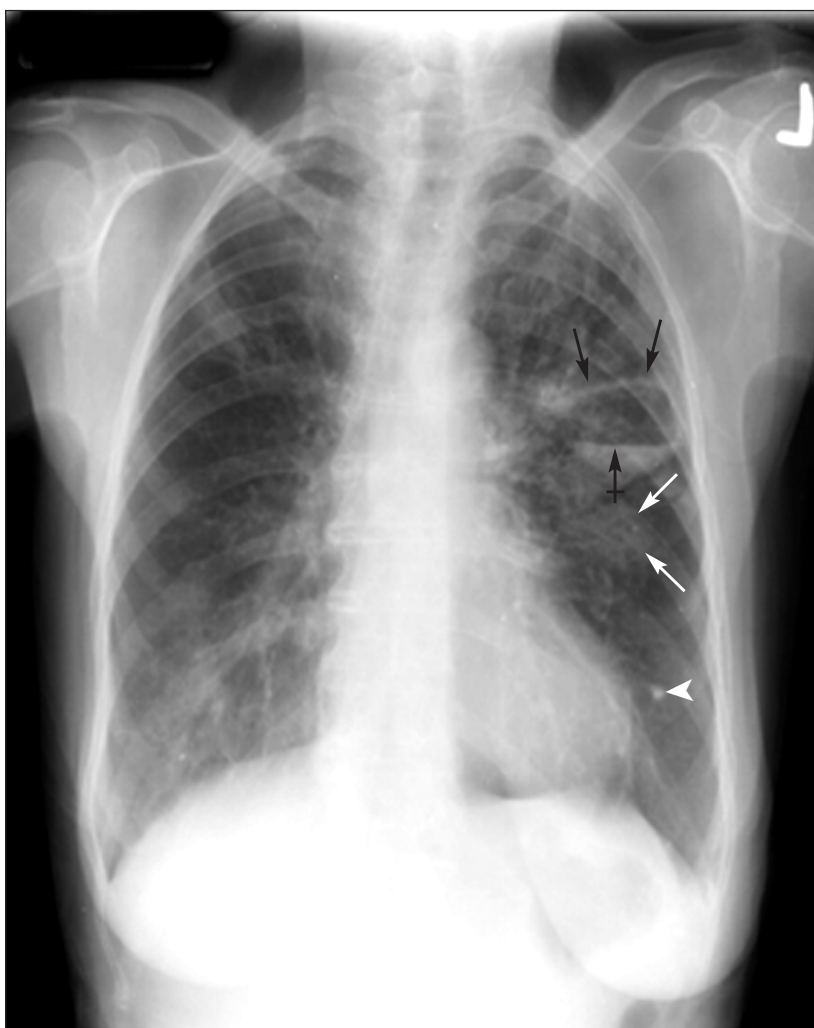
A prominent finding in this posteroanterior (PA) chest radiograph is a cyst in the superior segment of the left lower lobe (black arrows). The bar arrow designates the air-fluid level within the cyst. Such cysts are frequently caused by aspiration pneumonia. The calcified granulomas (arrowhead and two white arrows) are evidence of old inflammatory disease, as are the densities of fibrosis throughout both lungs. The rounded, hunched shoulders reflect the laxity of the patient's weakened shoulder muscles. Note: This orientation is correct. The reversed L is a technician error.
